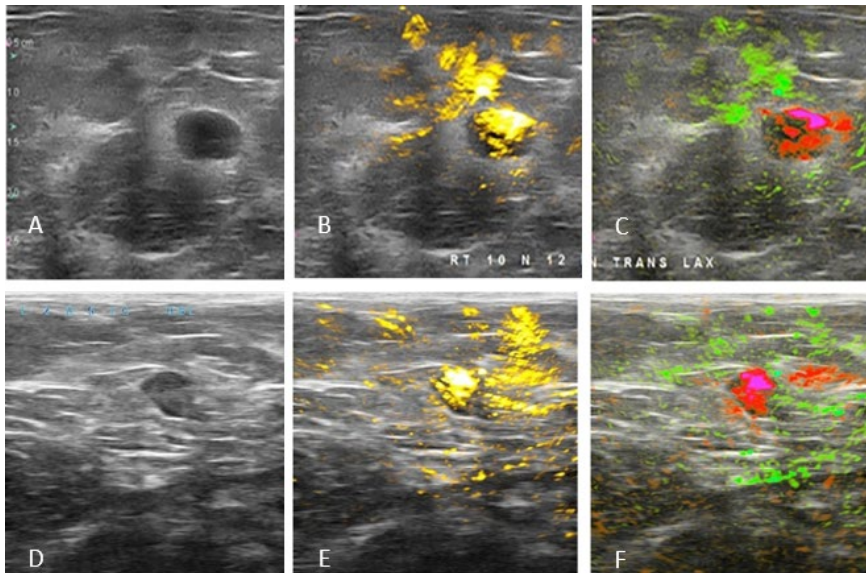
Optoacoustic technique in two different masses (A-C and D-F) where the functional imaging upgrades the lesions from BI-RADS 3 (gray-scale, traditional ultrasound) to BI-RADS 5). (adapted by Oraevsky et al.)
